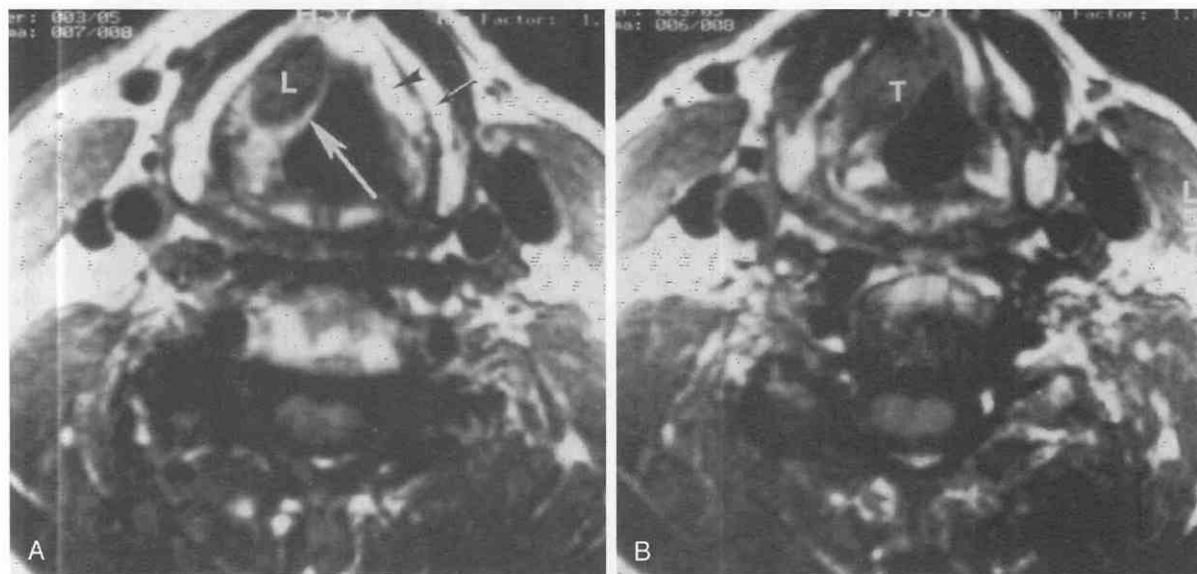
Saccular cyst (fluid-filled laryngocele). *A*, The saccular cyst (L) is seen filling the paraglottic space at the level of the false cord. Note the intact mucosa (white arrow). The paraglottic fat on the normal side (arrowhead) remains of high signal intensity. Fat is shown in the thyroid cartilage (black arrow). *B*, Slightly lower slice shows a tumor (T) filling the ventricle and causing the obstruction of the ventricular appendix, causing the saccular cyst. (From Curtin HD: MR and CT of the larynx. In Thrall JH [ed]: Current Practice of Radiology, 3rd ed. St. Louis, Mosby-Year Book, 1994.)
